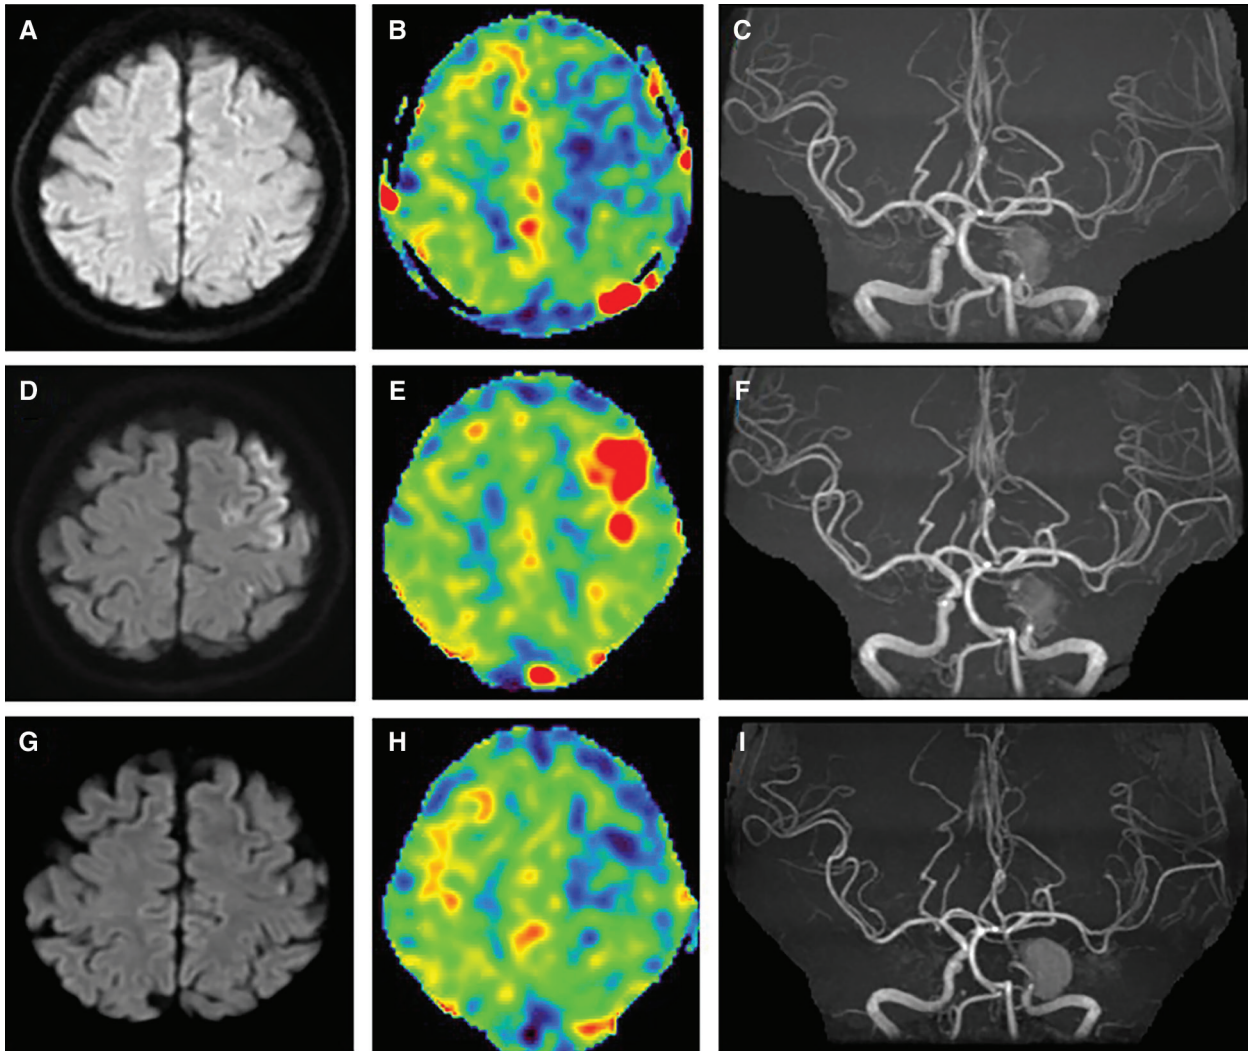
(A–C) MRI immediately after surgery. (A) There was no high signal intensity suggestive of cerebral infarction on DWI. (B) ASL showed low signal intensity, suggesting hypoperfusion. (C) On MRA, visualization of peripheral blood vessels was reduced. (D–F) MRI the day after surgery. High signal intensity localized in the left frontal lobe cortex on DWI (D) and at the same site on ASL (E) was detected. On
